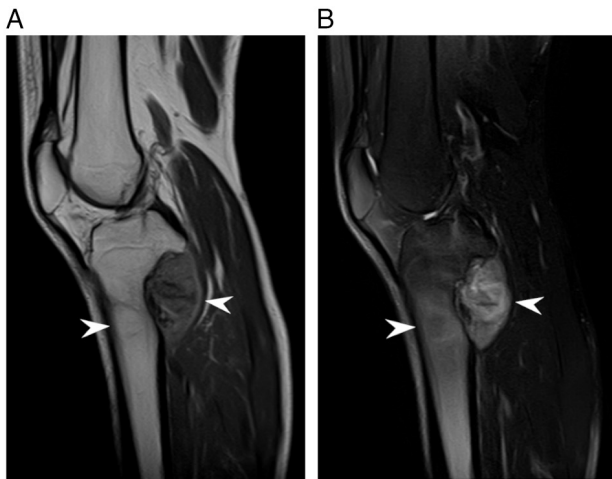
Sagittal magnetic resonance imaging of the primary tibial tumor. The tumor was present in proximal site of the metaphysis of the left tibia. The periosteal or intracortical envelopes from the tibial metaphysis to the epiphysis show (A) a lytic lesion of vague low intensity on T1-SE and (B) mild hyperintensity on T2-FSE (arrow heads pointing to the right), involving soft tissue mass protruding to the dorsal side of the lytic lesion (arrow heads pointing to the left).
